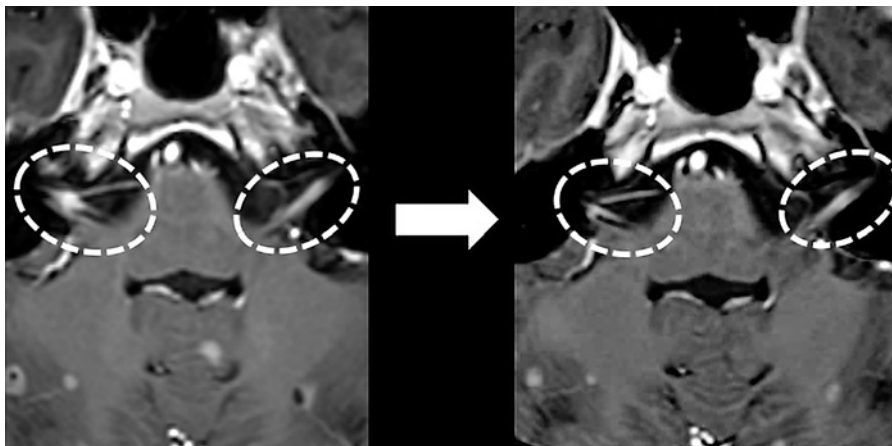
Changes in head contrast-enhanced magnetic resonance imaging findings. Contrast enhancement of the facial and vestibulocochlear nerves appeared to have reduced (dashed circles) after 2 cycles of chemotherapy.
